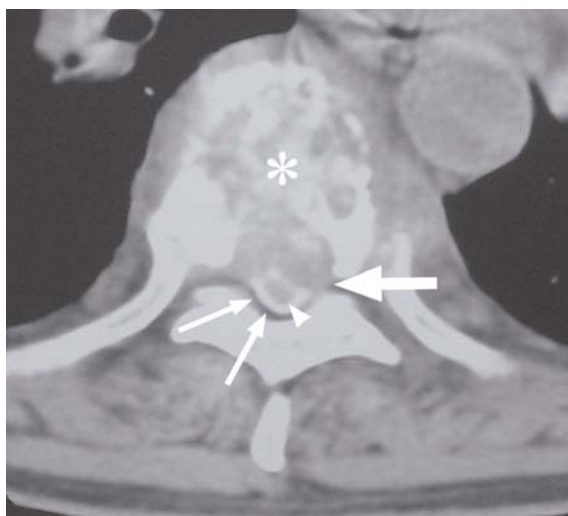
63-year-old man with pulmonary TB who presented with bilateral lower limb weakness. CT myelogram shows contrast material (small arrows) surrounding the compressed spinal cord (arrowhead). Compression is caused by the soft tissue component (large arrows) from the destroyed T9 vertebral body (*) due to TB.
